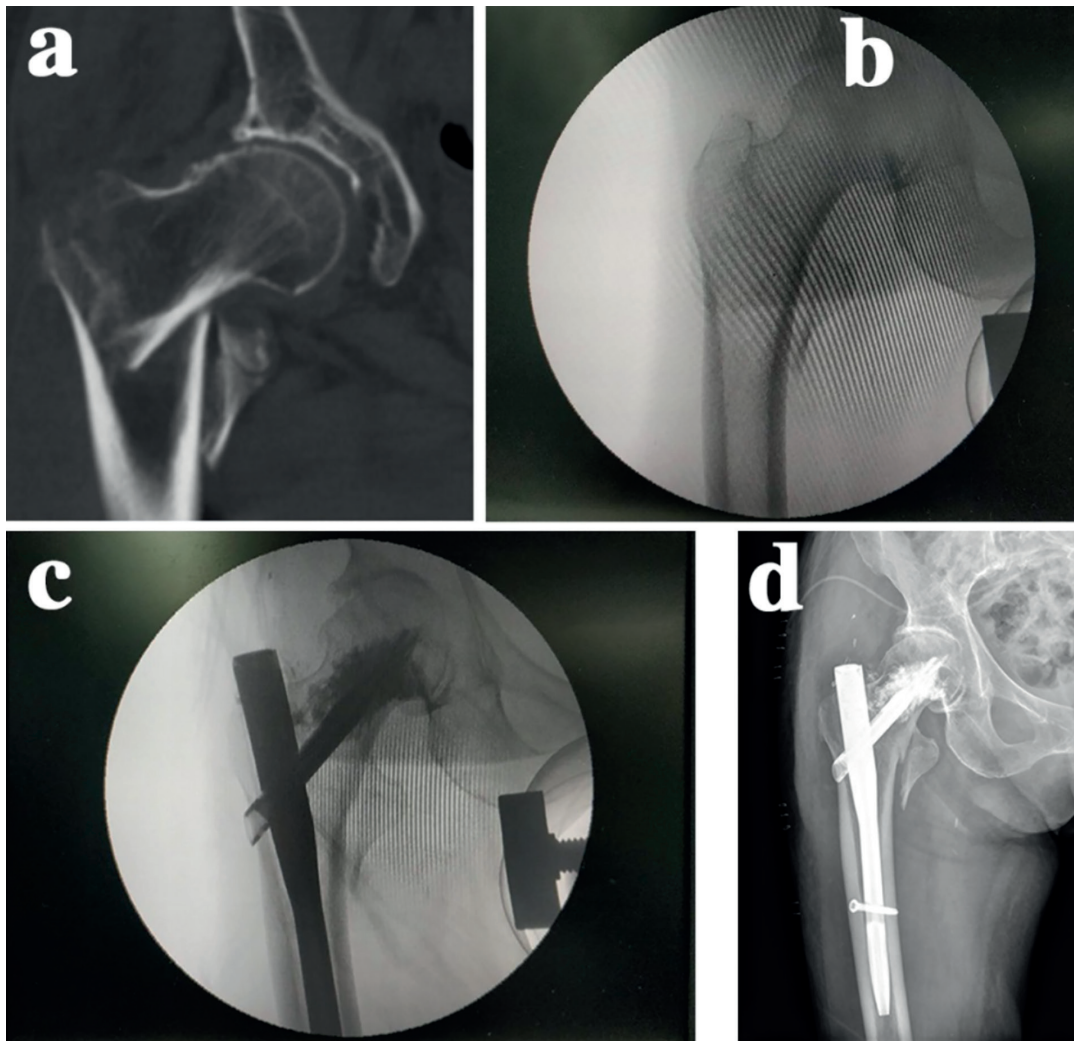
A 68-year-old man with right hip pain and limited movement due to a fall was admitted to the hospital for one day. a, Preoperative hip X-ray film showed a right femoral intertrochanteric fracture. b, Images after intraoperative fracture reduction. c, Intraoperative internal fixation and bone cement-enhanced imaging. d, The postoperative hip X-ray showed that the fracture reduction was good, and the bone cement was evenly dispersed in the femoral head.
